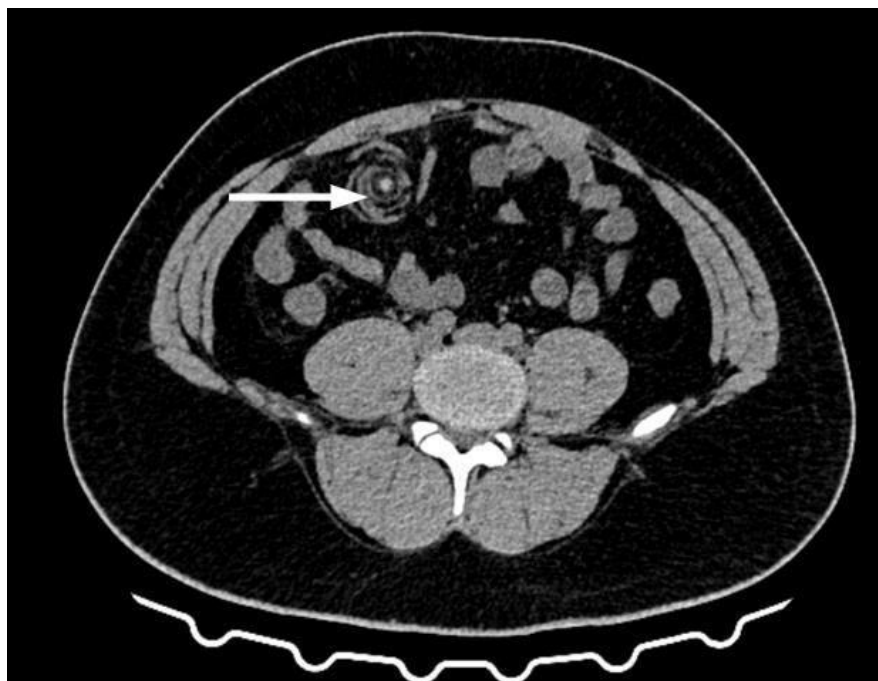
Plain CT abdominal axial section: Focal fat density mass in the right iliac fossa region of the greater omentum with linear central hyperdense structure (likely thrombosed vessels) with surrounding whirling streaks seen within this mass.
